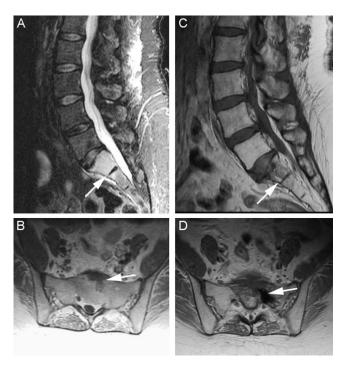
T1-weighted magnetic resonance images (MRIs) of the sacral lesion showing enhancement (arrow) in sagittal (A) and axial (B) views. Sagittal (C) and axial (D) T1-weighted MRIs of the sacral lesion after radiotherapy demonstrate no enhancement (arrow).
